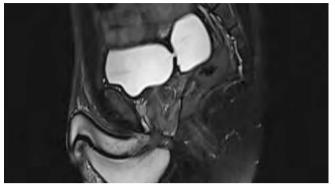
CT scan showing bladder diverticulum
